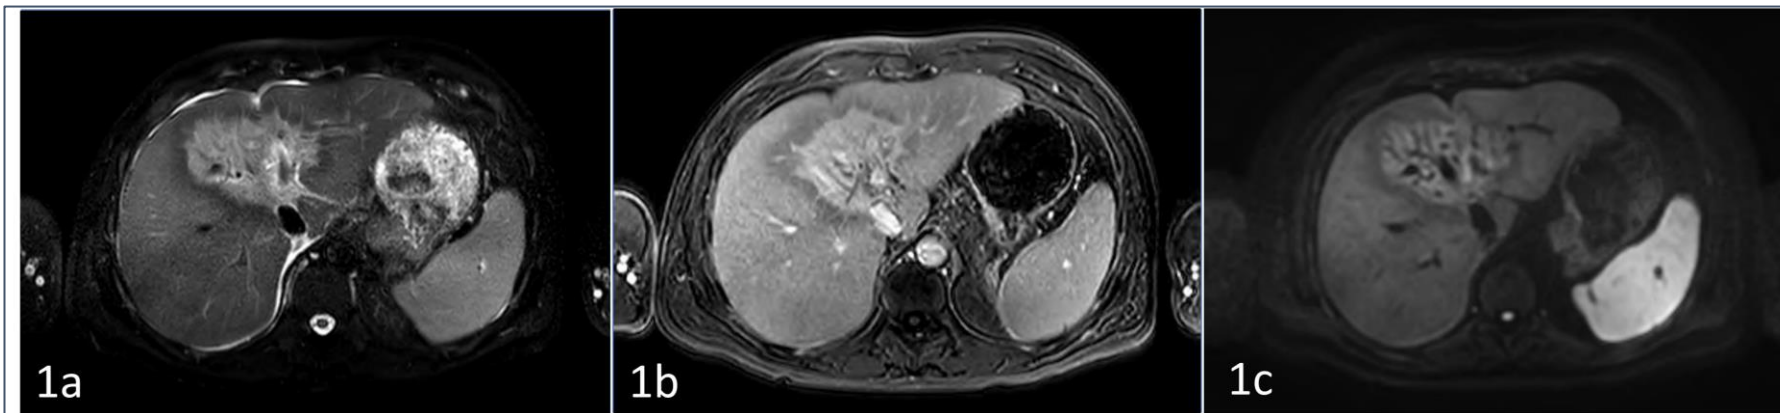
1a) Pre-contrast MR T2 weighted image showing a large central hepatic mass and lobular contour of liver consistent with cirrhosis. 1b) Post-gadolinium T1 fat-saturated MR image demonstrating enhancement of the liver lesion in the hepatic venous phase. The lesion showed high retention index of contrast on 5-minute delayed images (not included). 1c) Diffusion-weighted MR image showing the liver lesion with significantly restricted diffusion suggestive of infiltrative type of cholangiocarcinoma.
